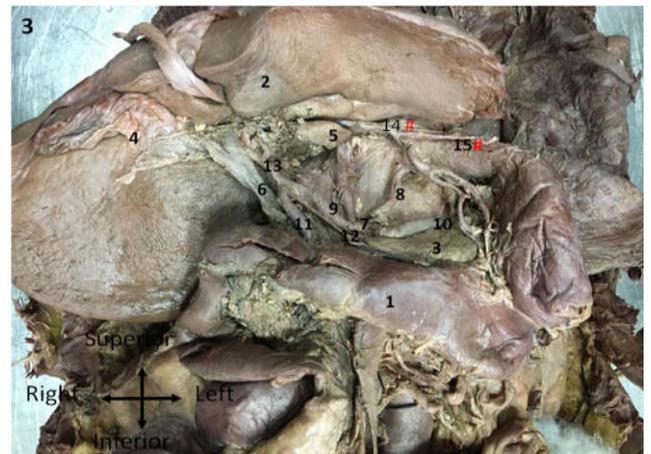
Variation in branching pattern of the CT arising from the abdominal aorta. CT was divided into left gastric artery, splenic artery and common hepatic artery. Note the left gastric artery gave an accessory left hepatic artery which was supplying left lobe of liver and cardiac part of stomach. 1- Stomach, 2- Left lobe of liver, 3- Pancreas, 4- Gall bladder, 5- Caudate lobe of liver, 6- Common bile duct, 7- Coeliac trunk, 8- Left gastric artery, 9- Common hepatic artery, 10- Splenic artery, 11- Gastroduodenal artery, 12- Right gastric artery, 13- Hepatic artery, 14-(#) Accessory left hepatic artery, 15-(#) Cardiac branch from accessory left hepatic artery
